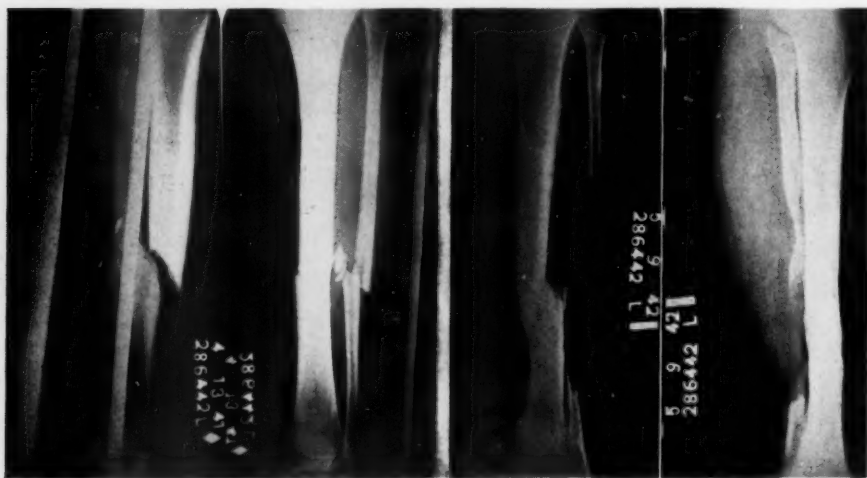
Anteroposterior and lateral roentgenograms of the tibia and fibula taken on admission.
